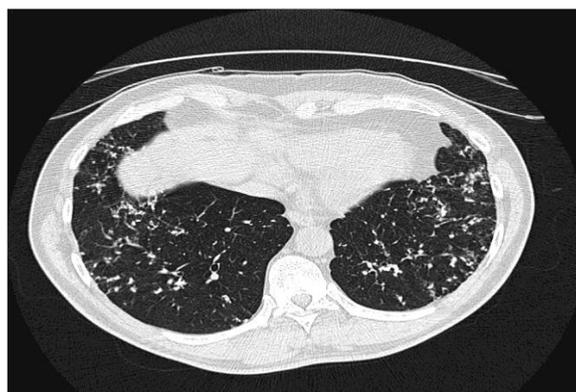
Radiographic findings in pulmonary alveolar microlithiasis. a) Chest radiograph depicting a fine, sand-like micronodular pattern with basilar predominance. b) High-resolution computed tomography with micronodules, interlobular septal thickening, subpleural emphysema with predominance of small cysts.
